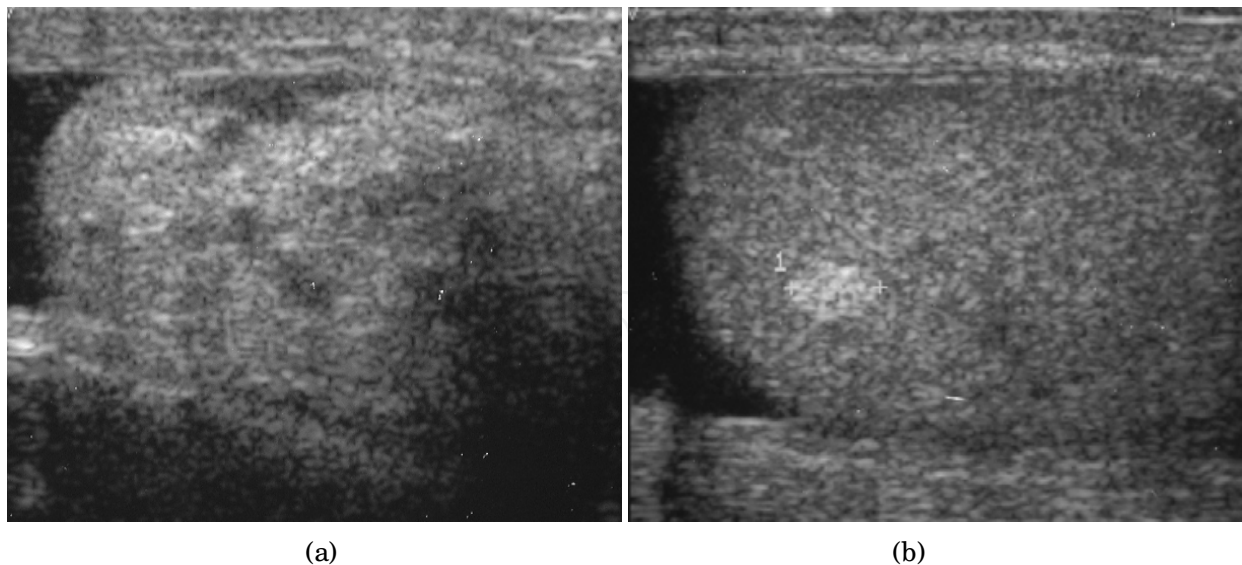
Lipoma at spermatic cord and testicle. (a) Longitudinal scrotal sonography of a 61 year-old patient shows a well defined hyperechoic nodule is seen in the scrotum. (b) Scrotal sonography of the same patient shows a hyper echoic nodule in the left testis, pathology proved that this is a lipoma too
